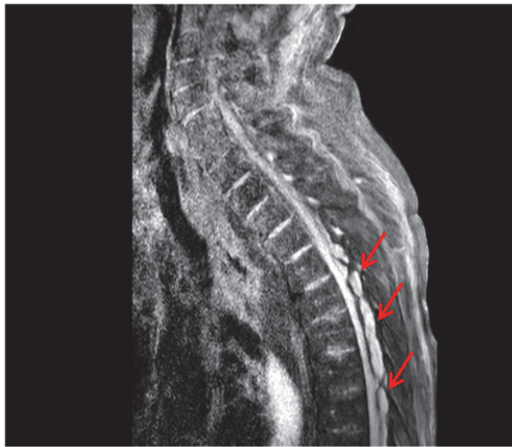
MRI with epidural hematoma compressing the spinal cord.
